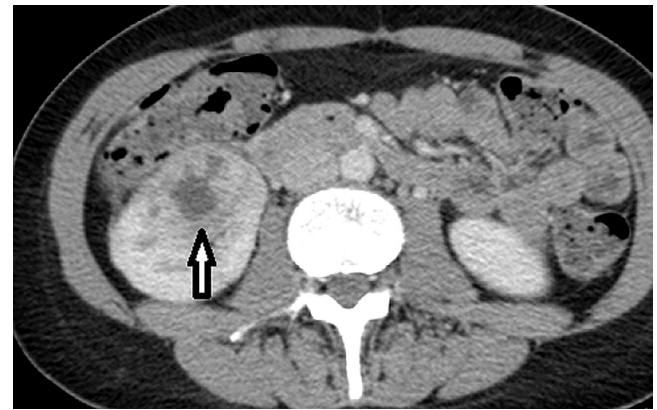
■ Renal abscess. A 30-year-old woman presents with symptoms of urinary infection with loin pain. CT demonstrates a thick-walled cystic lesion in the right kidney (see arrow) in keeping with an abscess. CT is particularly helpful for infections that involve the perinephric space which are not well demonstrated with US.
